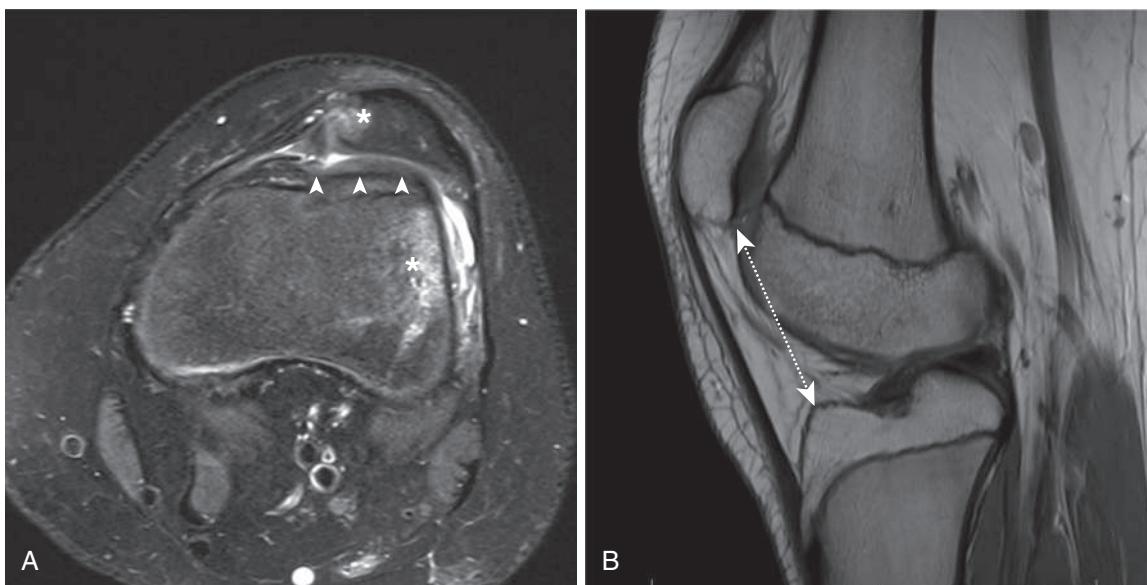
A 14-yr-old female with patellar instability. A, A T2-weighted fat suppression axial image through the mid-patella and proximal trochlea demonstrates the characteristic bone bruise pattern on the medial patella and along the lateral femoral condyle that occurs when the dislocated medial patella impacts the lateral femur (asterisks). Injury to the patellar attachment of the medial patellofemoral ligament is also visible at the medial patella. The patella is laterally subluxated in a dysplastic trochlea that is flat to slightly convex (arrowheads) instead of having a normal concave shape. B, A proton density weighted sagittal image through the center of the knee and patella demonstrates patella alta, with the distance from the anterior tibia to the inferior aspect of the patellar cartilage (dotted line) being much longer than the length of the patellar cartilage.
